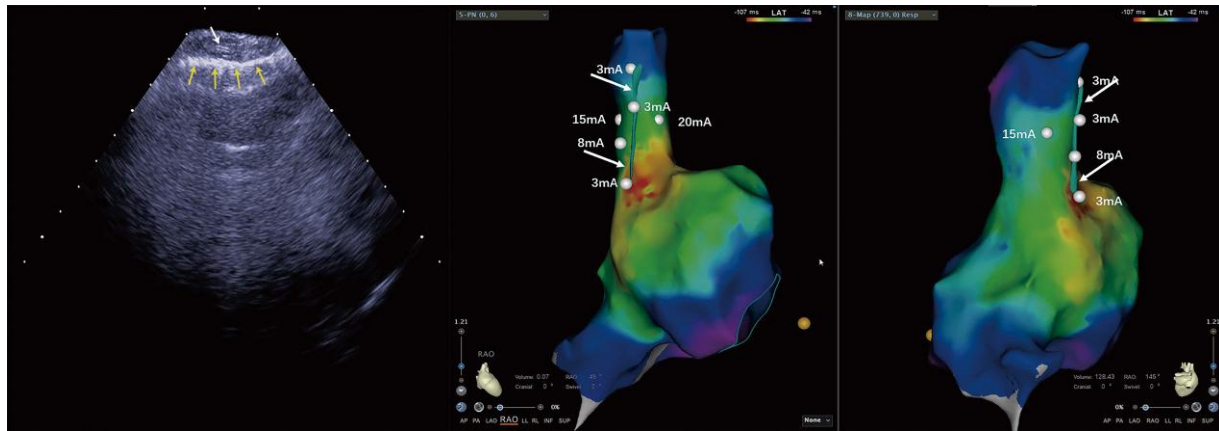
The lowest pacing threshold for right phrenic nerve (RPN) capture. The lowest pacing threshold for RPN capture is achieved when the ablation catheter is placed close to the 'straw' pattern in the superior vena cava (SVC). Left image: the RPN imaging under intracardiac echocardiography (ICE). The up row of arrow indicates the RPN, and the bottom row of arrows indicates the mediastinal pleura. Middle and right images: the same patient's 3D activation maps of the right atrium (RA) and SVC in right anterior oblique (RAO) 45° and RAO 145° views. The dots indicate the pacing site and the arrows indicate the RPN integrated into the electroanatomical shell.
